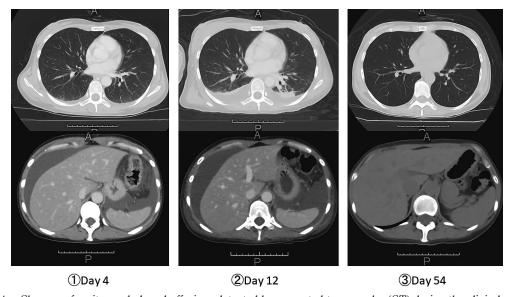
Changes of ascites and pleural effusions detected by computed tomography (CT) during the clinical course (Day 4, Day 12, Day 54).
